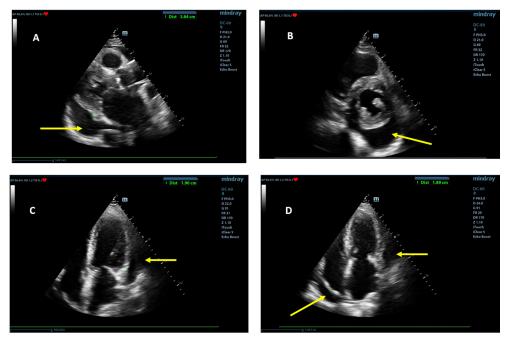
c.4. Large amount of pericardial fluid (arrow) noticed as a transonic, echo-free space between pericardium sheets noticed between heart and aorta (3.84 cm, image A: 2D, parasternal long axis view), posterior to the left ventricle (image B: 2D, parasternal short axis view), posterolateral to the left ventricle (1.9 cm; image C: apical 4-chambers view), posterior to the right atrium (1.89 cm, image D: 2D, apical 4-chambers view)
